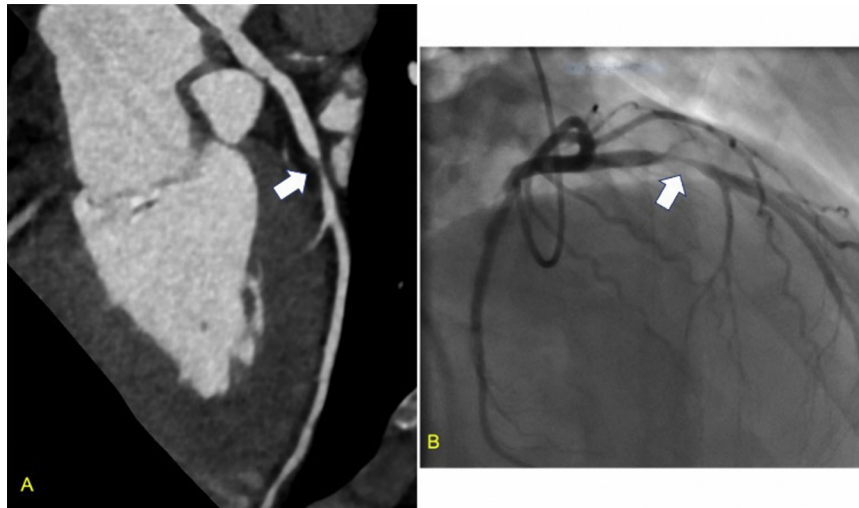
Coronary CT angiography. Curved multiplanar reformatted image of the left anterior descending (A) demonstrating a severe mid-vessel stenosis (arrows) that corresponded to severe stenosis on invasive coronary angiography (B).
